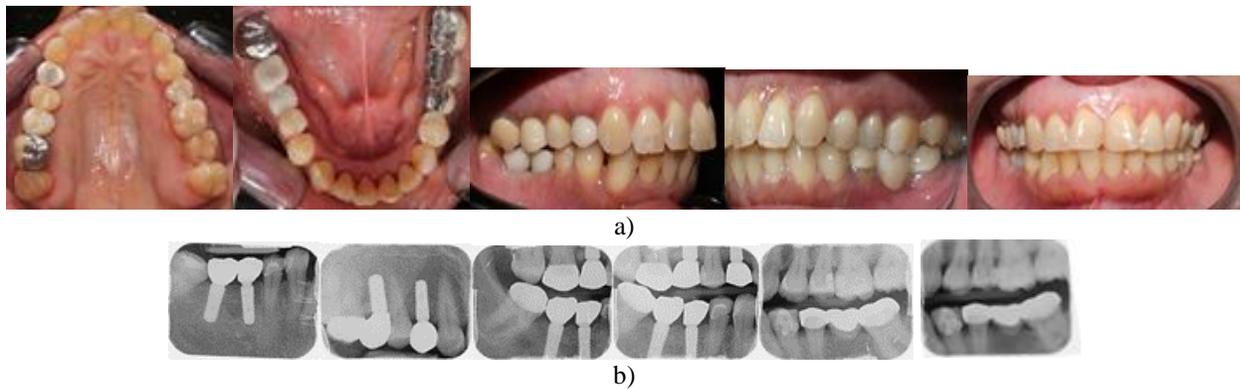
a) Zirconia screw-retained implant crowns #14,16,46 and 47. b) Zirconia screw-retained implant crowns radiographs #14,16,46 and 47.
